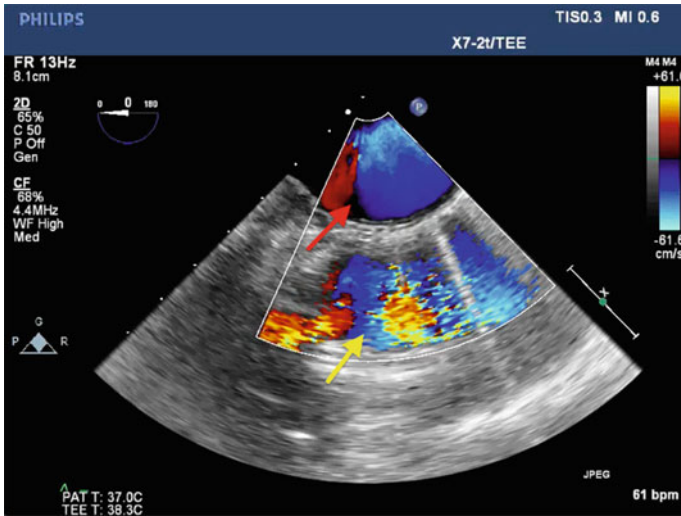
Descending aortic view demonstrating mirroring artifacts that can occur in both two dimensional imaging and color flow Doppler imaging. A mirroring artifact (*yellow arrow*) of the true aorta (*red arrow*) is displayed here with CFD
